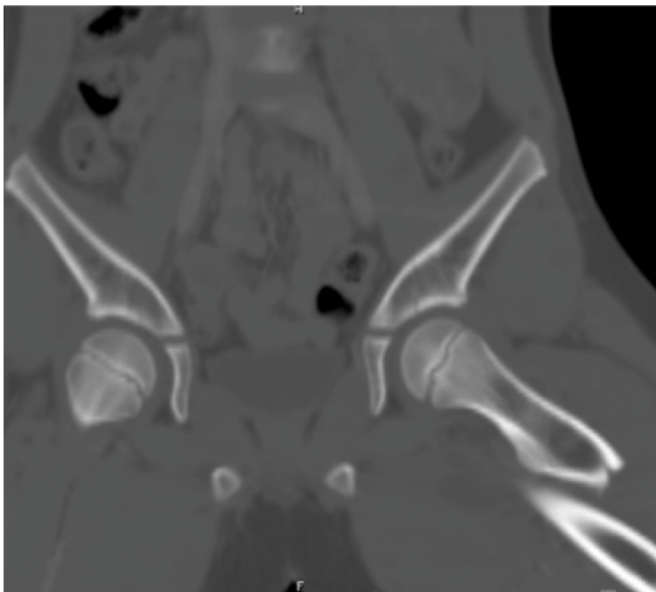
[A] Anteroposterior (AP) radiograph of the left femoral shaft fracture and [B] coronal view of computed tomography imaging.
